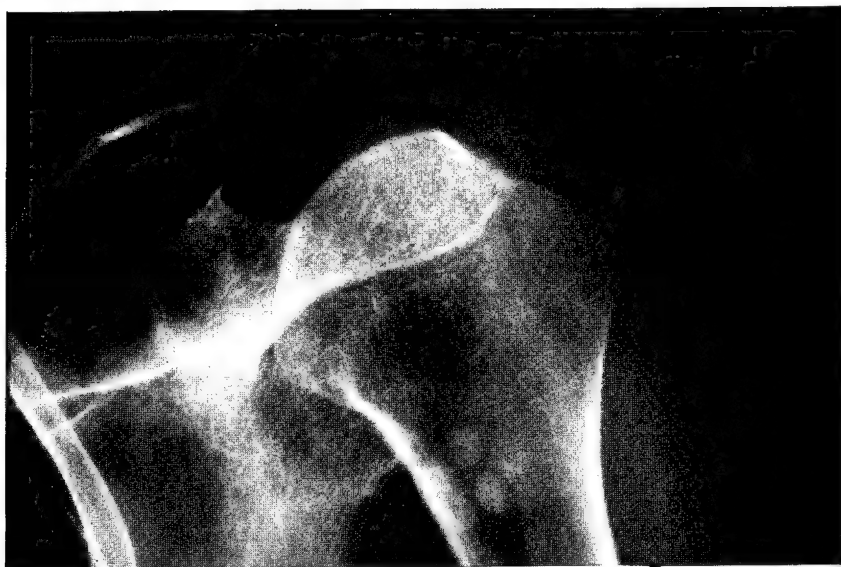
Anteroposterior roentgenogram of shoulder showing severe grooving of the humeral head resulting in "hatchet-head deformity."
